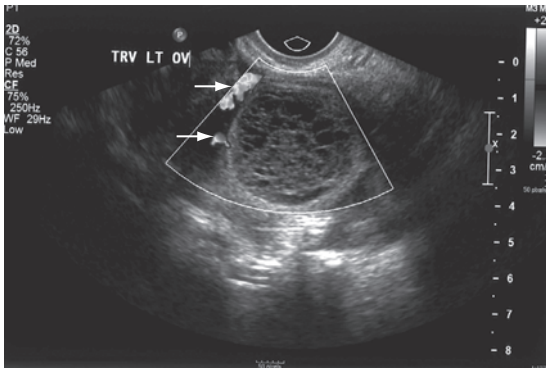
Hemorrhagic cysts with a spectrum of sonographic appearances. Transvaginal images. (A) Hemorrhagic cyst with reticular pattern of internal echoes and multiple septations. Color Doppler demonstrates vascularity (arrows) outside the mass.
